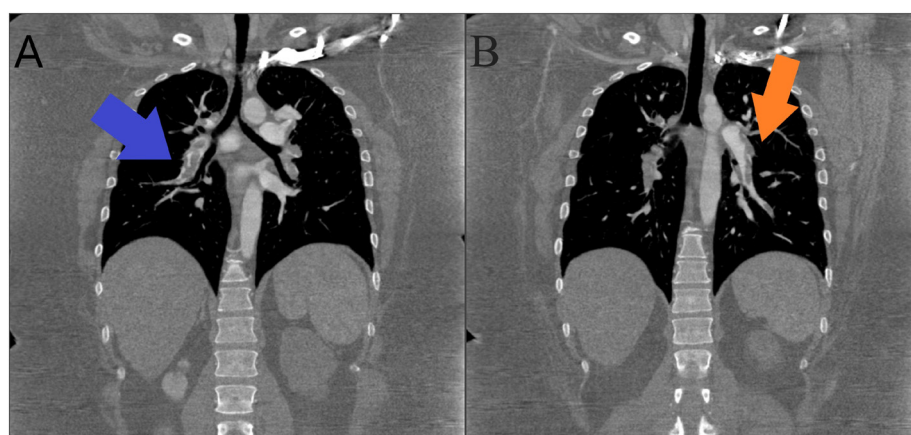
Contrast-enhanced computed tomography of the chest. (A) Thrombosis of the right pulmonary artery (blue arrow). (B) Thrombosis of the left pulmonary artery (orange arrow).
